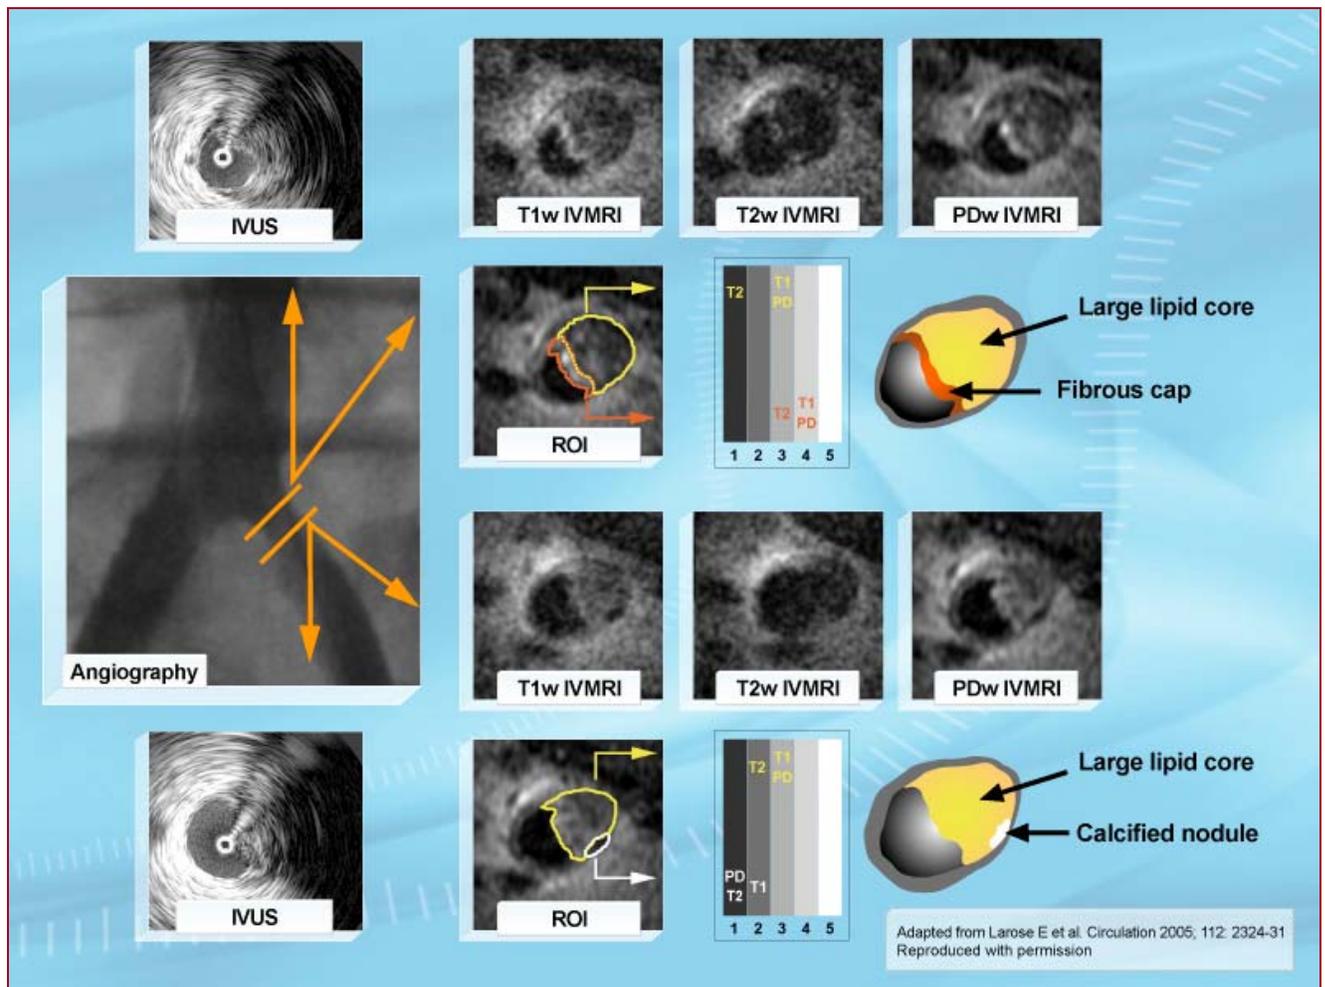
Intravascular magnetic resonance imaging (IVMRI) of common iliac artery in vivo. Angiogram (left) of a common iliac artery and corresponding intravascular ultrasound (IVUS) and IVMRI images of the iliac artery at its origin (top half) and 6 mm distal to the bifurcation (bottom half). In both segments, the artery is characterized by angiographic narrowing and IVUS that images the outside edges of the artery and plaque incompletely, whereas the corresponding IVMRI depicts the entire plaque morphology. The validated approach to tissue characterization ex vivo applied to this in vivo study demonstrates a predominantly lipid core with overlying fibrous cap at the origin of the iliac artery (top half) and a large lipid core with a calcium nodule in the more distal segment (bottom half).
